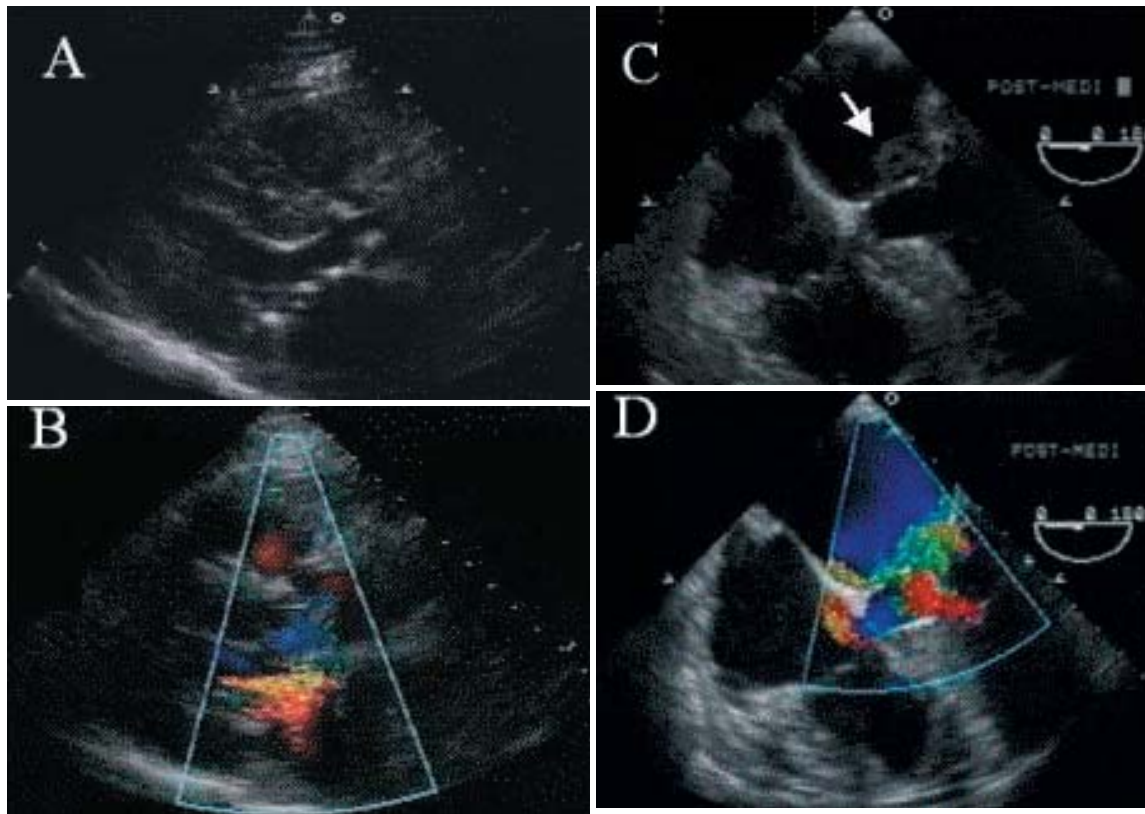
Echocardiograms taken on admission in 2003
